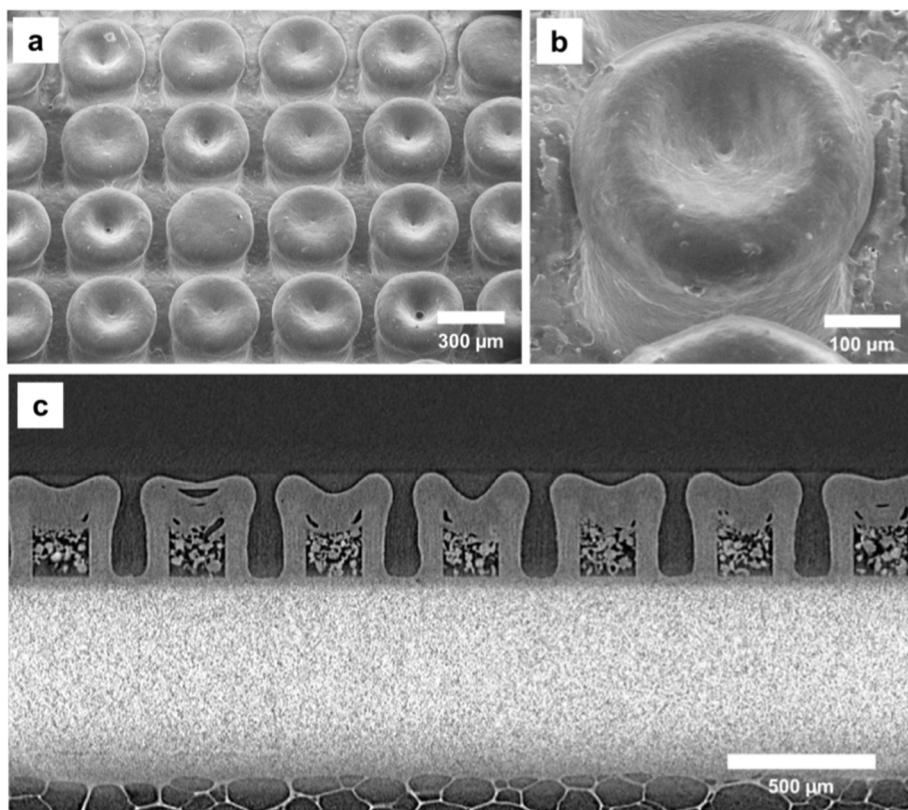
Morphological characterization of loaded and coated D-MCs. (a) and (b): SEM images of D-MCs coated with Eudragit® L100 onto the cavity of the drug-loaded D-MCs. (c): X-ray μ CT cross-sectional view of the drug-loaded and coated D-MCs.
